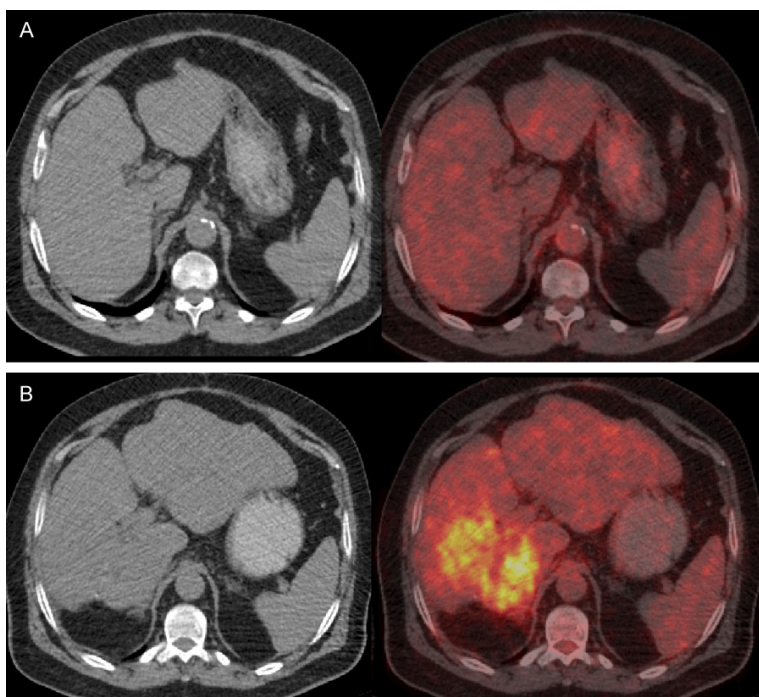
FDG PET images of a patient with HCC. Initial study (top, A) shows homogenous density and isometabolic activity in the liver lesion seen on MR (not shown here). Biopsy showed well-differentiated HCC. Four years later after treatment, PET/CT showed heterogeneous density and increased metabolic activity due to recurrent tumor (tumor SUVmax: 8.9, liver SUVmean: 2.5) in the right hepatic lobe (B). PET findings indicate progression of tumor from well-differentiation to poor differentiation.
